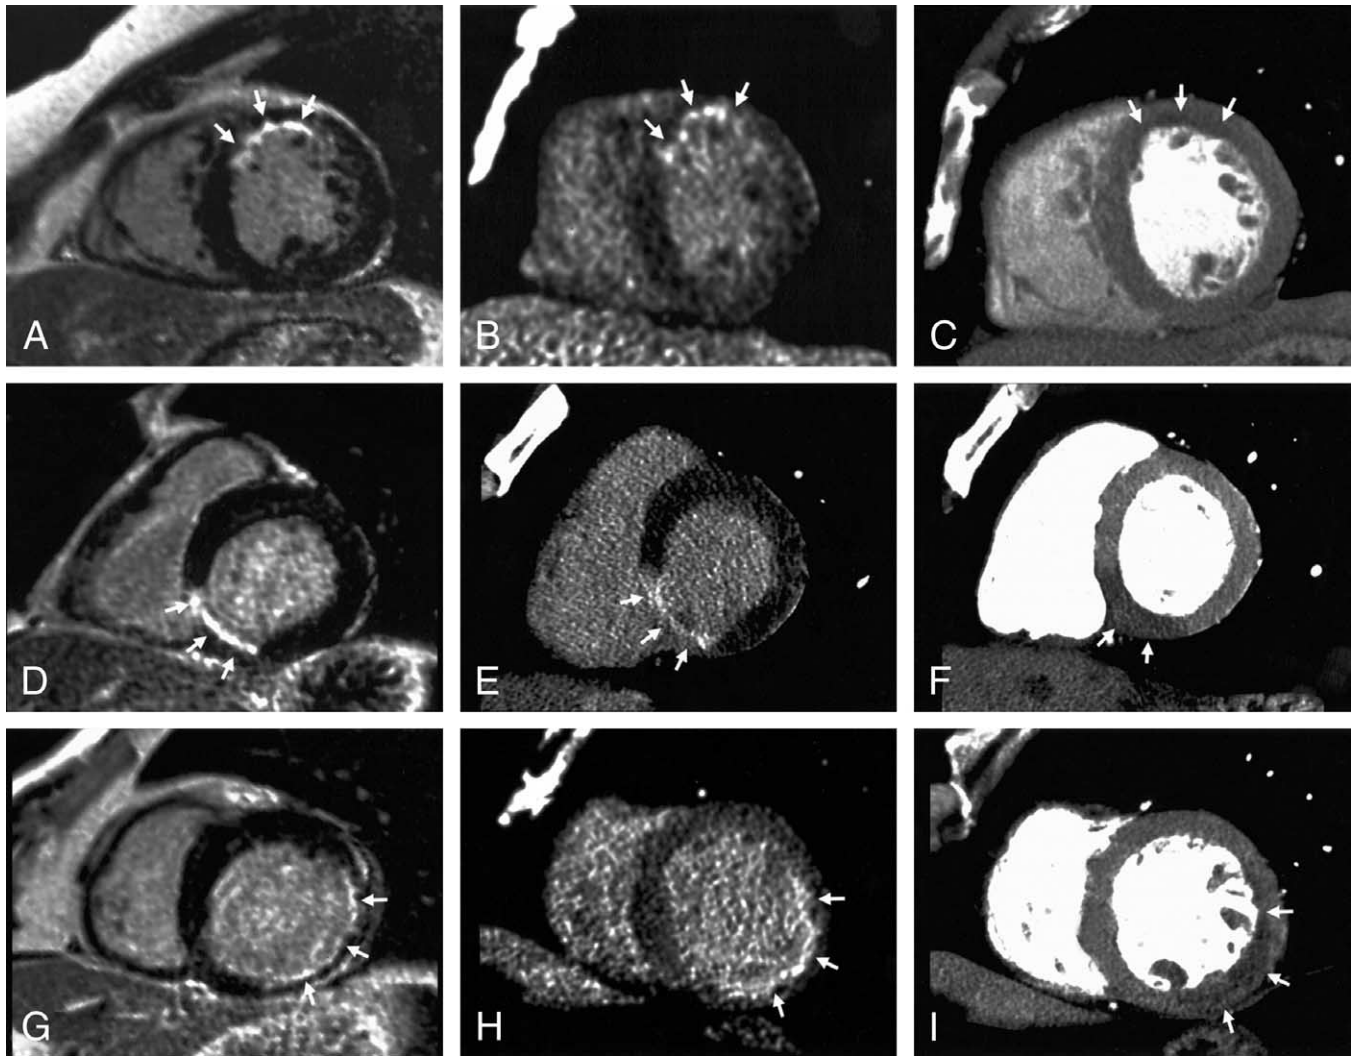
Short-axis view magnetic resonance imaging (MRI) (A,D,G) and short-axis multislice spiral computed tomography (MSCT) images (B,C,E,F,H,I) in three different patients with acute myocardial infarction (MI) (arrows) attributable to left anterior descending (A to C), right coronary artery (D to F), and left circumflex artery (G to I) occlusion after successful revascularization. There was an excellent agreement between delayed-enhancement MRI (A,D,G) and late-enhancement MSCT (B,E,H). Agreement with arterial-phase MSCT (C,F,I) was slightly worse.
